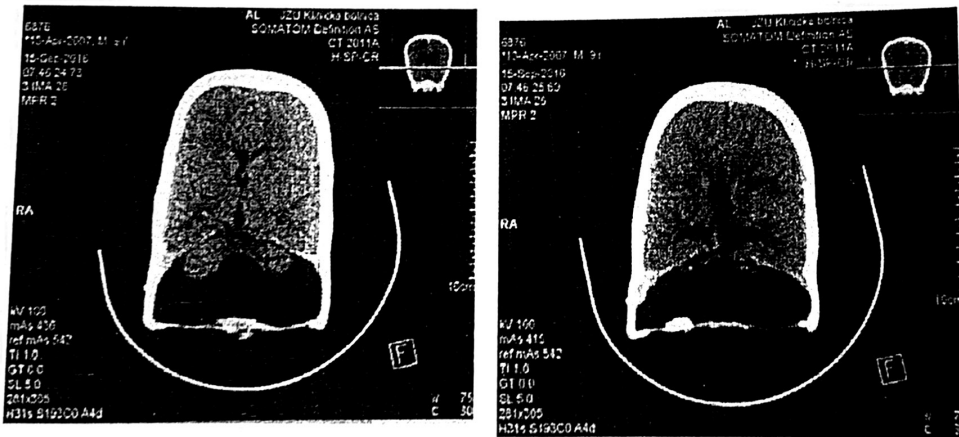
Late post-operative CT-scan of our patient
